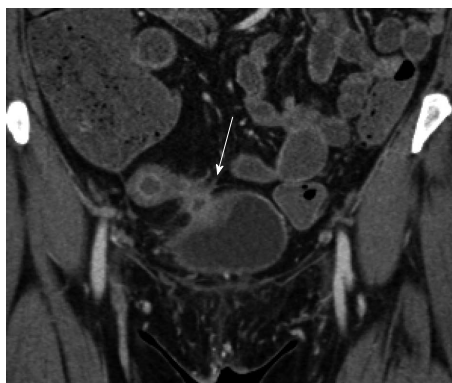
Enterovesicular fistula. Fifty-two-year-old female with Crohn's disease. Coronal contrast-enhanced computed tomography image demonstrates a markedly thickened, hyperemic loop of bowel in the pelvis, in keeping with acute Crohn's related inflammation. The bowel loop directly abuts the bladder, which is focally thickened (arrow) at the site of contact, although no gas was identified in the bladder. The patient was ultimately proven to have an enterovesicular fistula.
